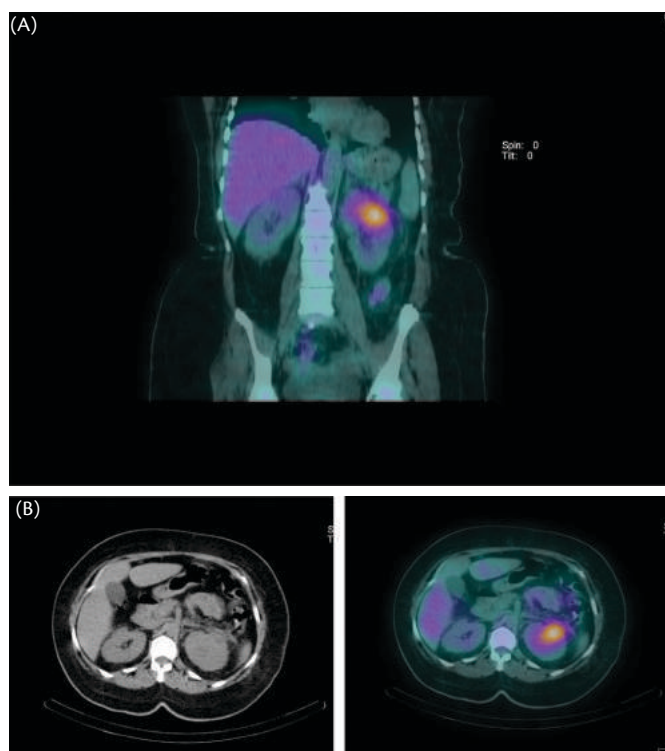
Gallium SPECT CT imaging in pyelonephritis. Coronal (A) and transverse (B) images are shown.
